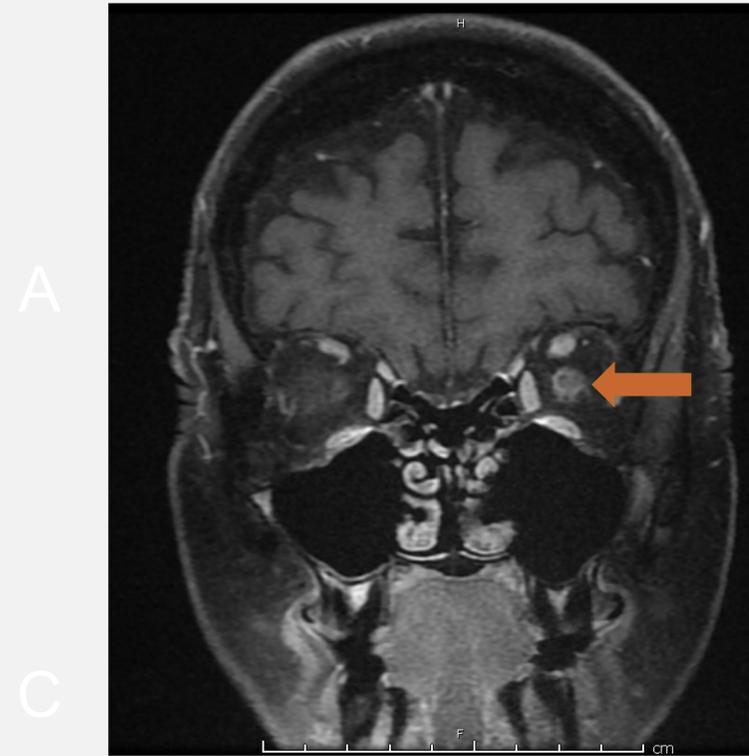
Postcontrast T1 coronal fat-suppressed MRI shows enhancement and thickening of the left optic nerve sheath
